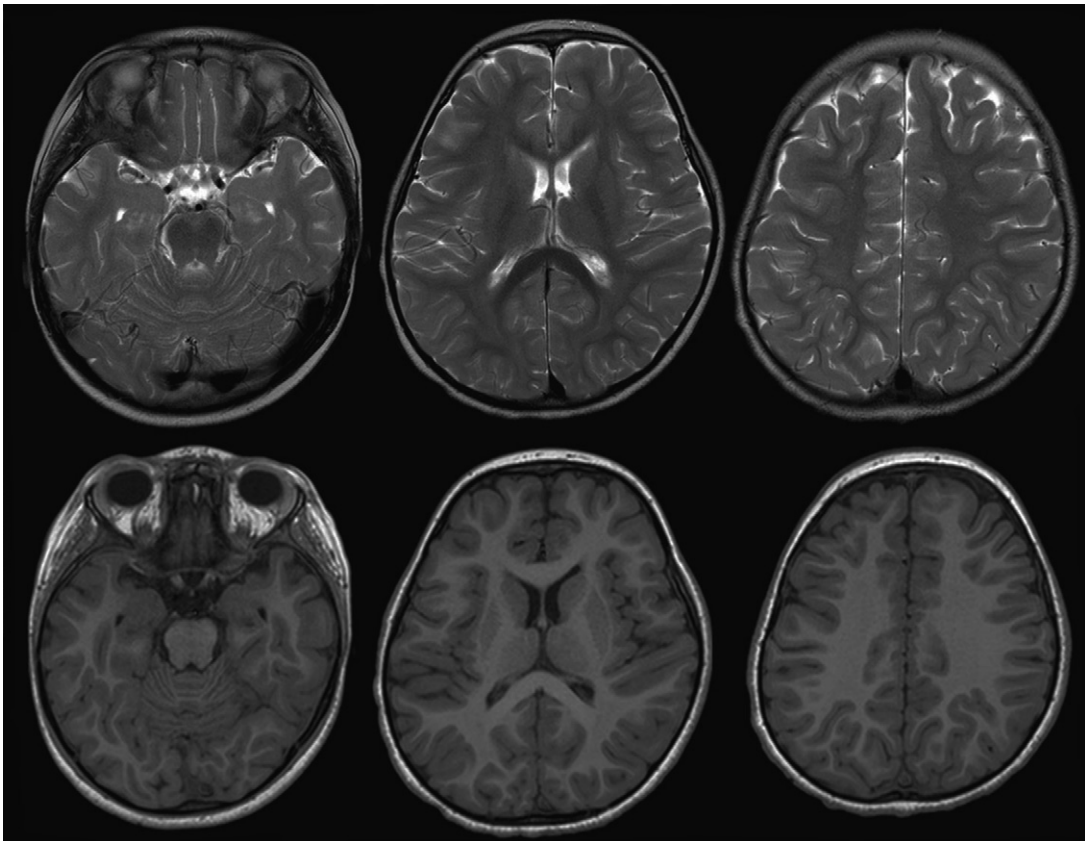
Imaging of myelination. By 3 years of age, myelin should be complete and adultlike in appearance on both T1-weighted and T2-weighted sequences.
